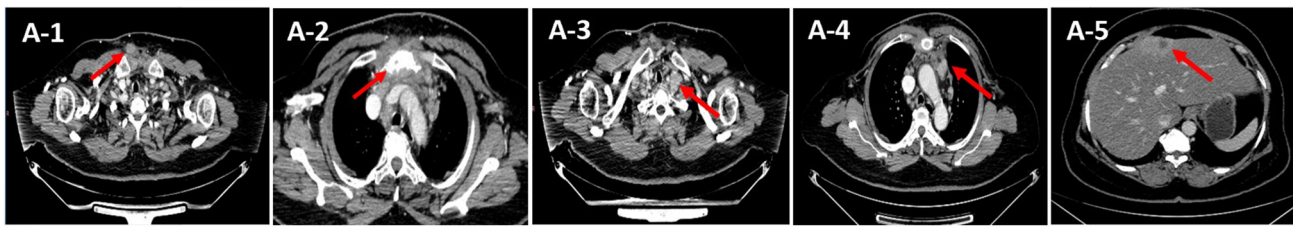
Chest and abdominal CT scans showing metastatic lesions. (A-1) Chest wall metastasis (1.8x1.4 cm). (A-2) Sternal bone destruction with soft tissue mass formation (4.2x3.5 cm). (A-3) Left supraclavicular lymph node metastasis (2.0x2.5 cm). (A-4) Mediastinal lymph node metastasis (2.2x1.5 cm). (A-5) Liver metastasis (3.0x3.0 cm). Red arrows indicate metastases. CT, computed tomography.
